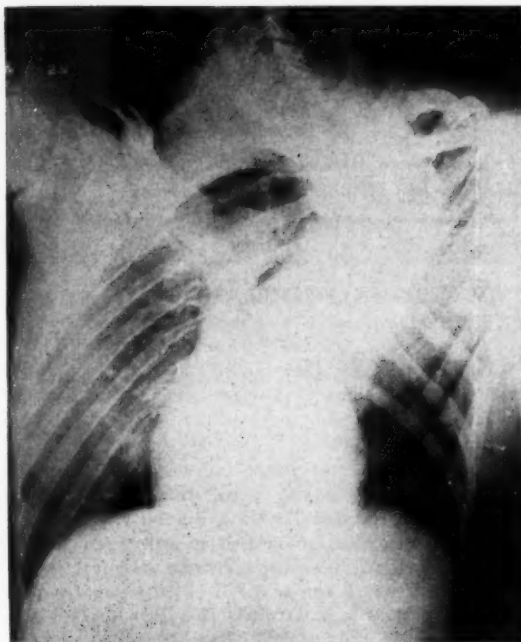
Oblique x-ray chest showing the dorsal kyphoscoliosis.
